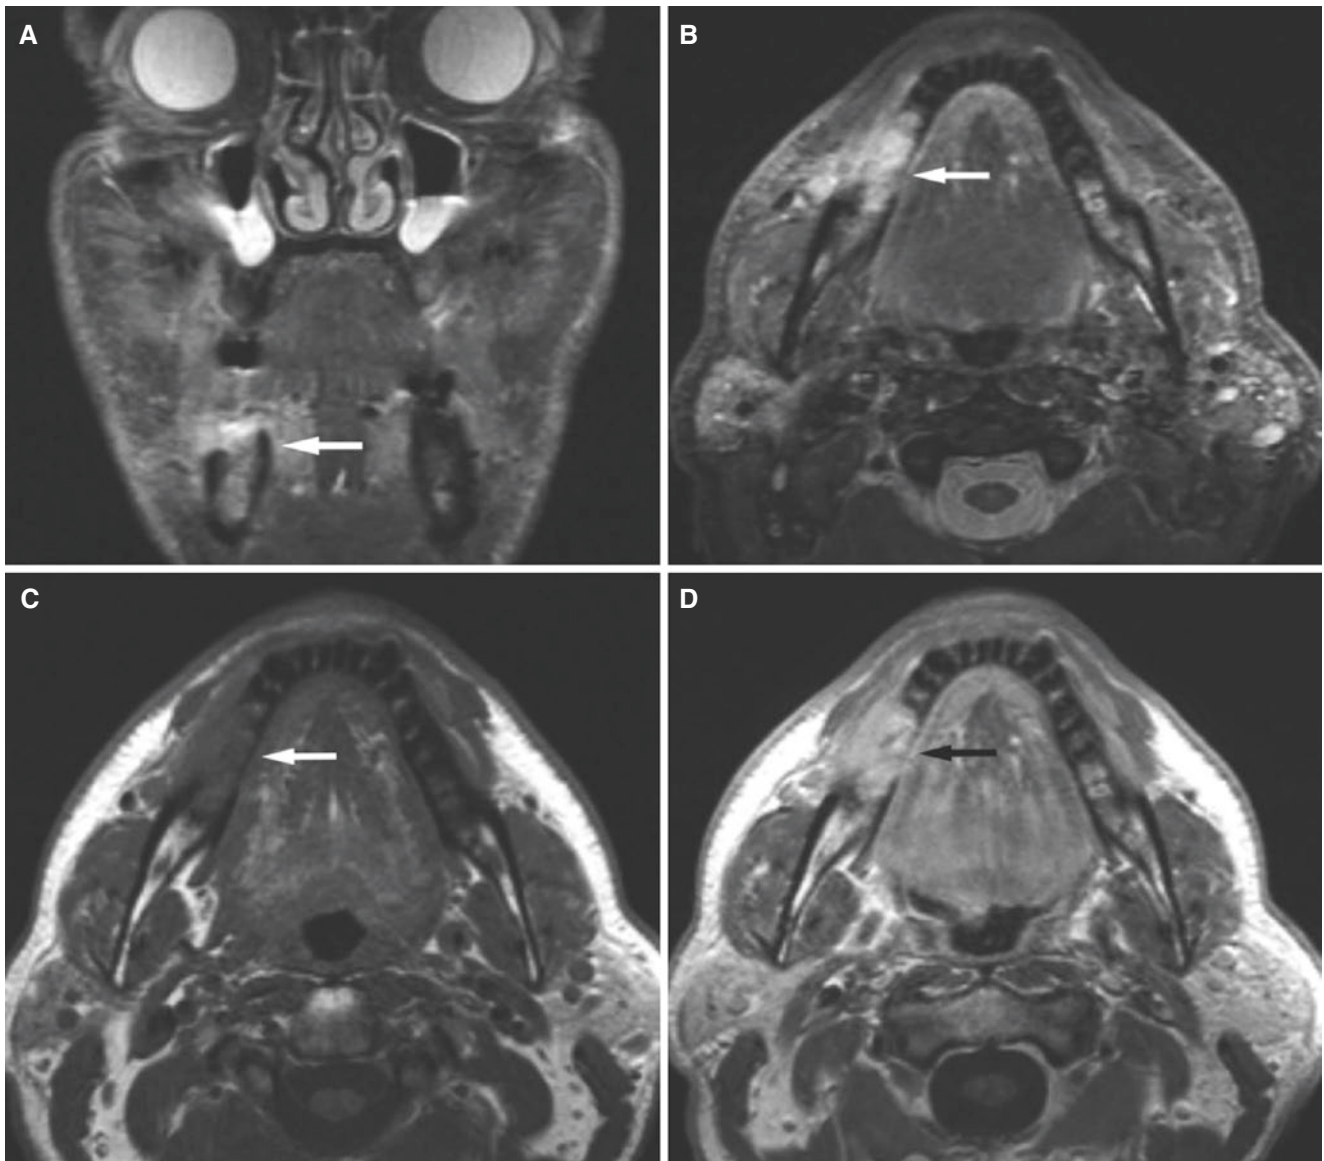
Squamous cell carcinoma, mandible; 55-year-old male with oral leukoplakia several locations in oral cavity for many years, then developed pain and soreness, and cancer in tooth socket after molar extraction (panoramic view and CT were negative). (A) Coronal STIR MRI shows small area of high signal in cranial part of the alveolar bone
